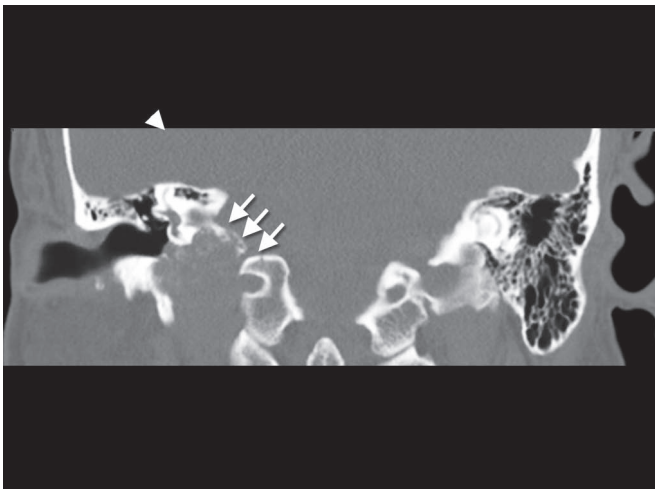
High-resolution computed tomography of the temporal bone, coronal views, demonstrating a glomus jugulare extending toward the posterior fossa. Note the irregular borders, the moth-eaten appearance (small white arrows) and the erosion of the floor of the hypotympanum (arrowhead).
